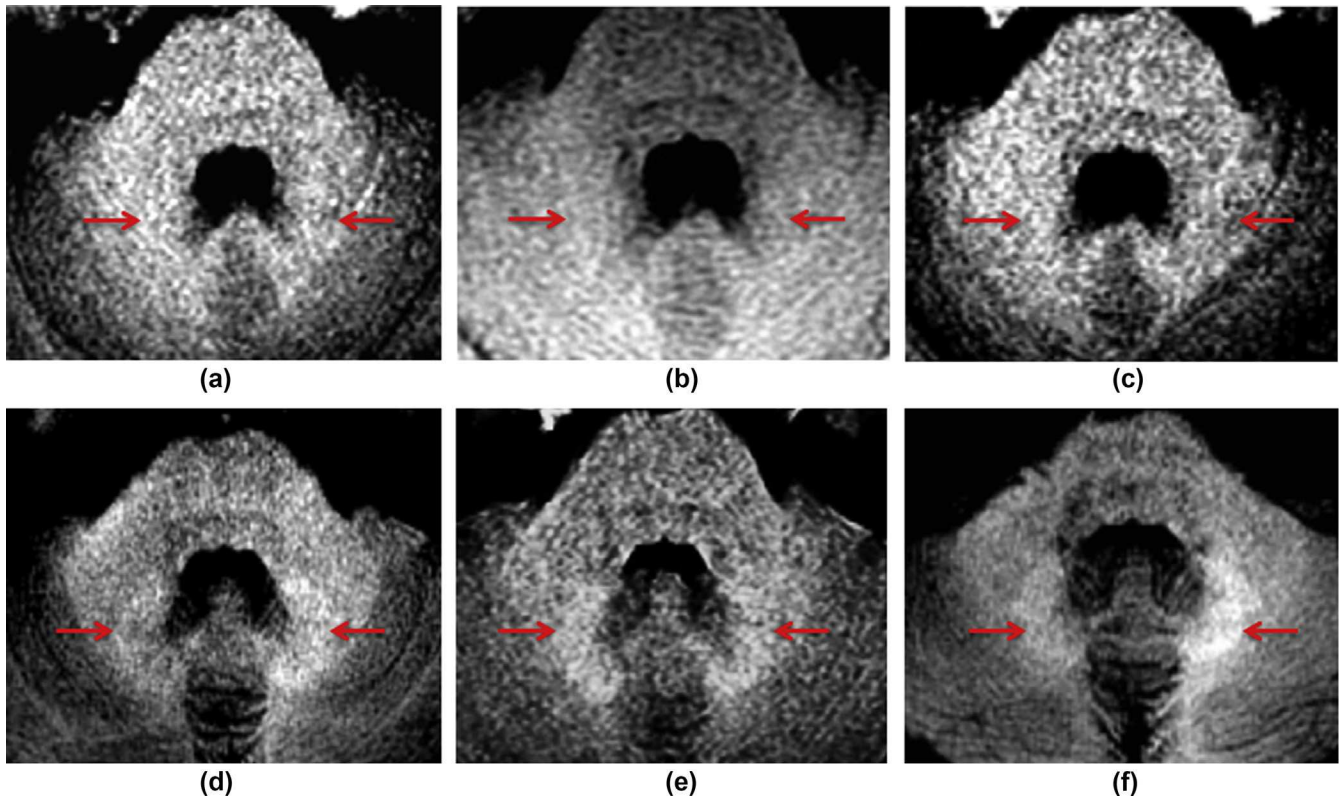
Increasing T1-weighted hyperintensity in the dentate nuclei following repeated GBCA administration. Axial pre-contrast T1-weighted images in a 13-year-old girl with non-Hodgkin lymphoma. She received six MRI examinations with gadopentetate dimeglumine over an 18-month period ((a–f), respectively).
